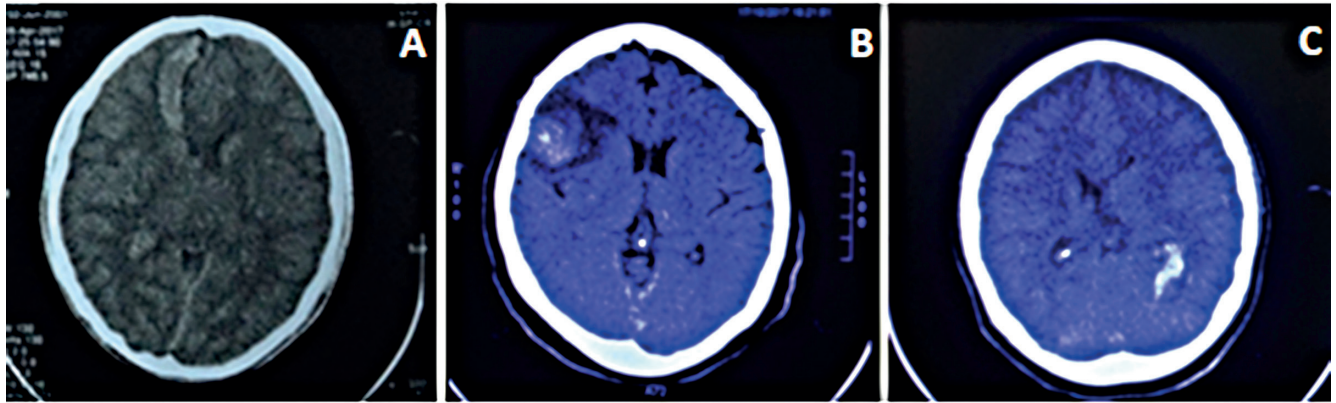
CT scans of patients who developed hemorrhagic vascular stroke after presumed botropic accidents. (A) Case 1, CT scan of the skull showing intraparenchymal hemorrhage in the right frontal region with perilesional edema. (B) Case 2, CT scan of the brain revealing a hypodense lesion in the right frontal lobe, cortical–subcortical, and perilesional edema. (C) Case 3, CT scan of the skull demonstrating hyperdensity in the posterior horn of the left lateral ventricle, with dilation of the homolateral temporal horn, related to the hemoventricle. CT: computed tomography.
